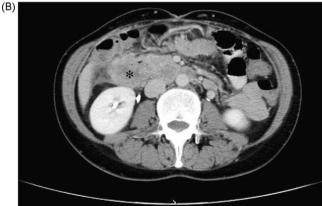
(A) In the non-enhanced abdominal CT, a long, straight, slightly hyperdense lesion was seen in the duodenum, indicating a foreign body such as a toothpick (black arrows). (B) In the enhanced abdominal CT, intra-abdominal abscess formation was noted (asterisk).
